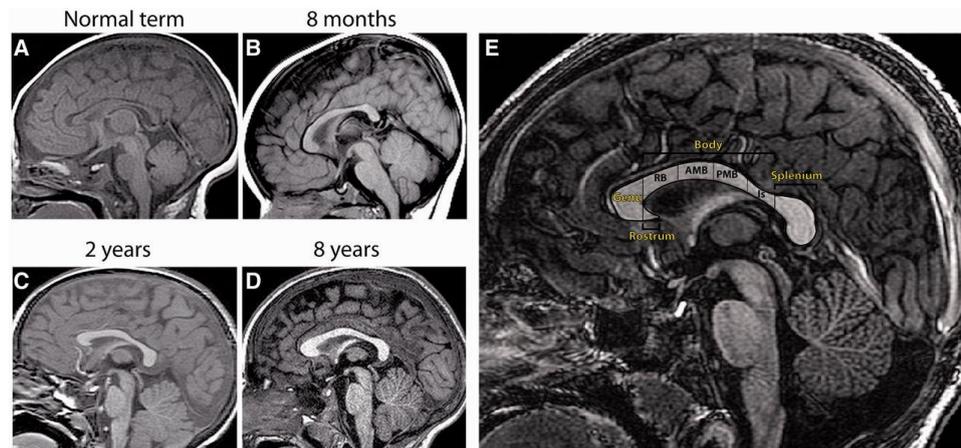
Brain T1-weighted magnetic resonance images in sagittal projection, showing the physiological conformation of the corpus callosum in the newborn at term (A), at 8 months (B), at 2 years (C), at 8 years (D) and in the adult (E).⁹
